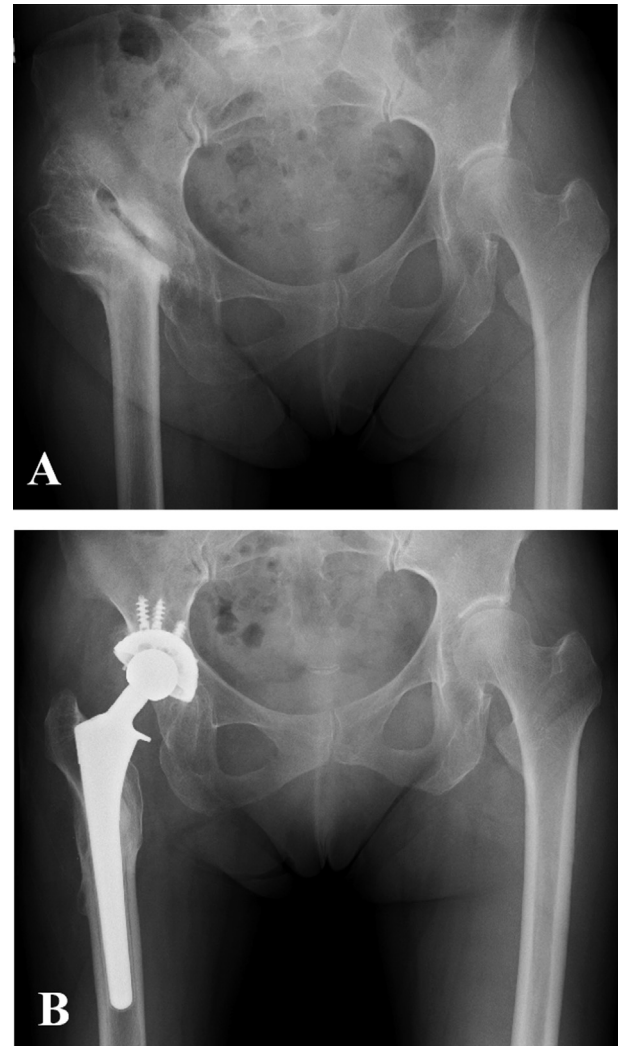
Pre- and postoperative radiographs of the right hip joint of a 61-year-old woman. (A) After Schanz osteotomy of the right femur. (B) Five years after total hip arthroplasty combined with subtrochanteric corrective shortening femoral osteotomy.
